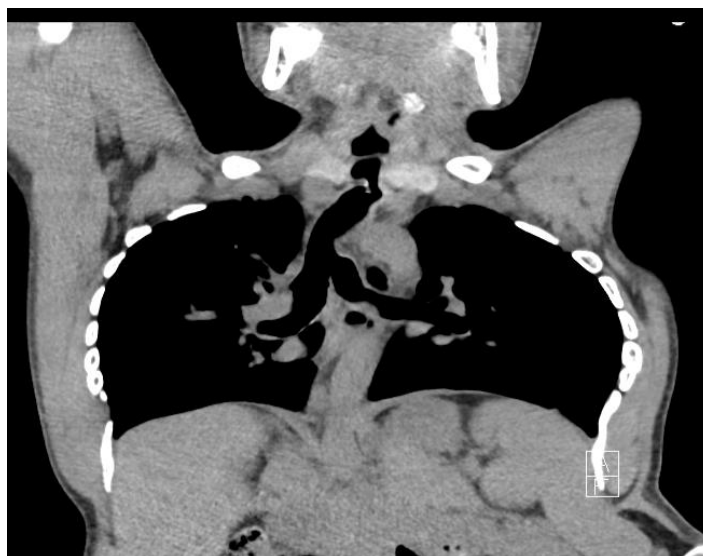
Coronal cut of the computed tomography scan of thorax showing multiple stenoses.
